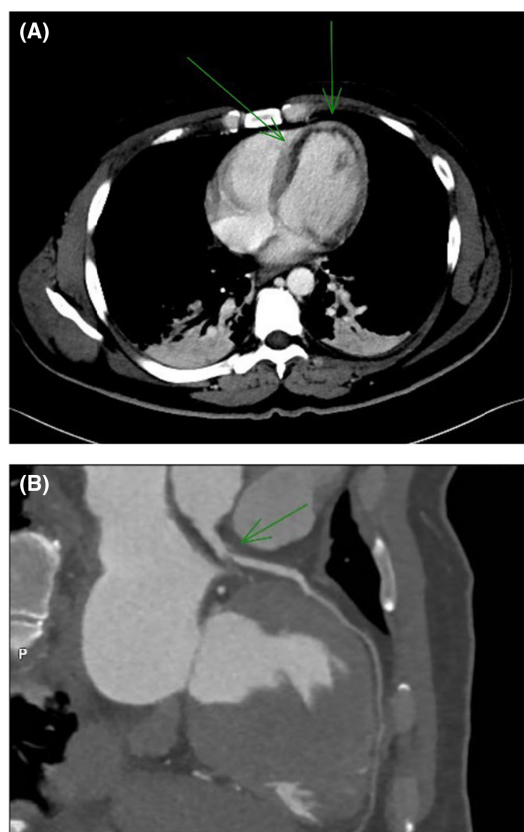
Computed tomography (CT) angiography images at (A) on admission shows a septal and apical wall subendocardial hypo-enhancing region is present along the region of the left anterior descending artery. The CT angiogram at (B) shows the proximal left anterior descending artery with the short segment of the circumferential hypoattenuating lesion, representing an intramural hematoma (most likely) or a noncalcified plaque (less likely).
